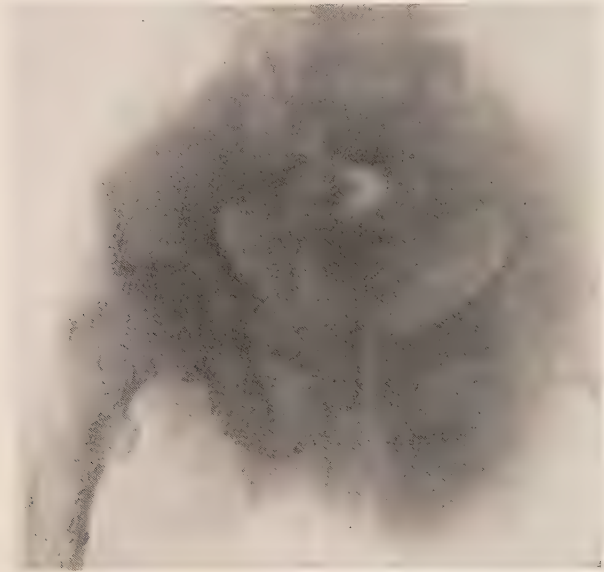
Osteosarcoma of left ischium. (Roentgenogram of Dr. G. C. Bird.)
